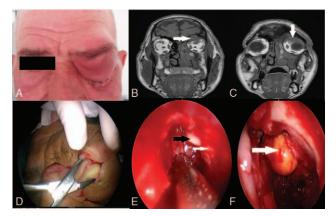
(A) Clinical appearance of the patient (case 2) was presented. (B) White arrow shows the upper eyelid abscess in T1 weighted MRI scan. (C) White arrow demonstrates the left orbital abscess in T1 weighted MRI scan. (D) External incision and drainage of the upper eyelid abscess was presented. (E) Black arrow demonstrates the endoscopic transnasal drainage of the left orbital abscess after incision to the orbital periosteum, white arrow shows the left orbital fat tissue. (F) White arrow presents the left orbital fat tissue after incision to the orbital periosteum and drainage of the abscess.
